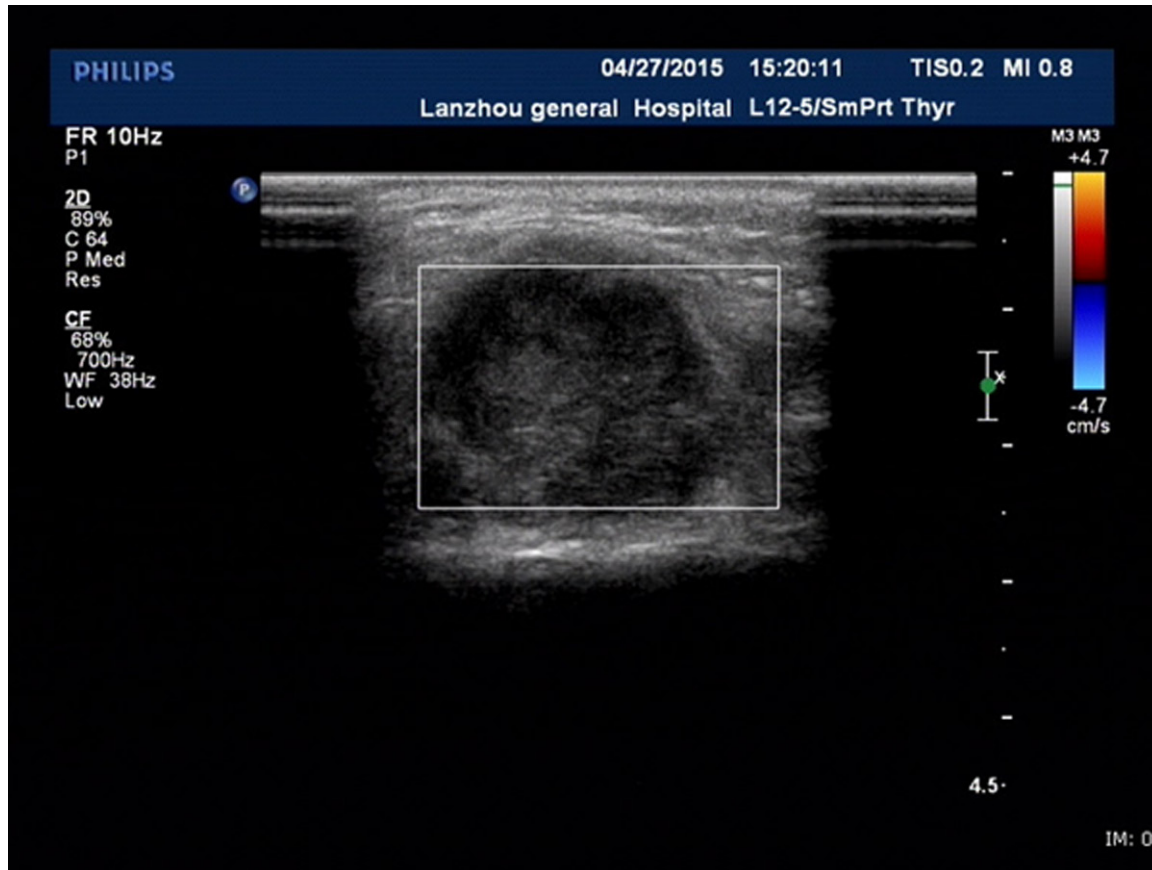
Ultrasound showed several hypoechoic nodules in the swelling of right parotid gland with a larger size of 2.4 × 2.4 cm, which were diagnosed by mixed tumors.
